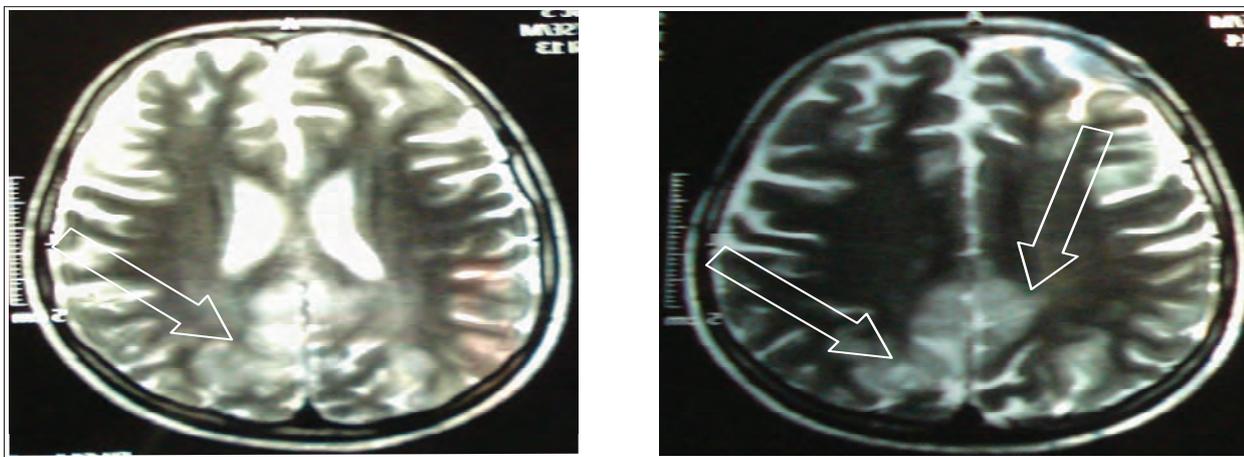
Axial FLAIR image revealing bilateral gyriform cortical and subcortical hyper-intensities at the parieto-occipital regions and subtle hyper-intensity at the right occipital region
